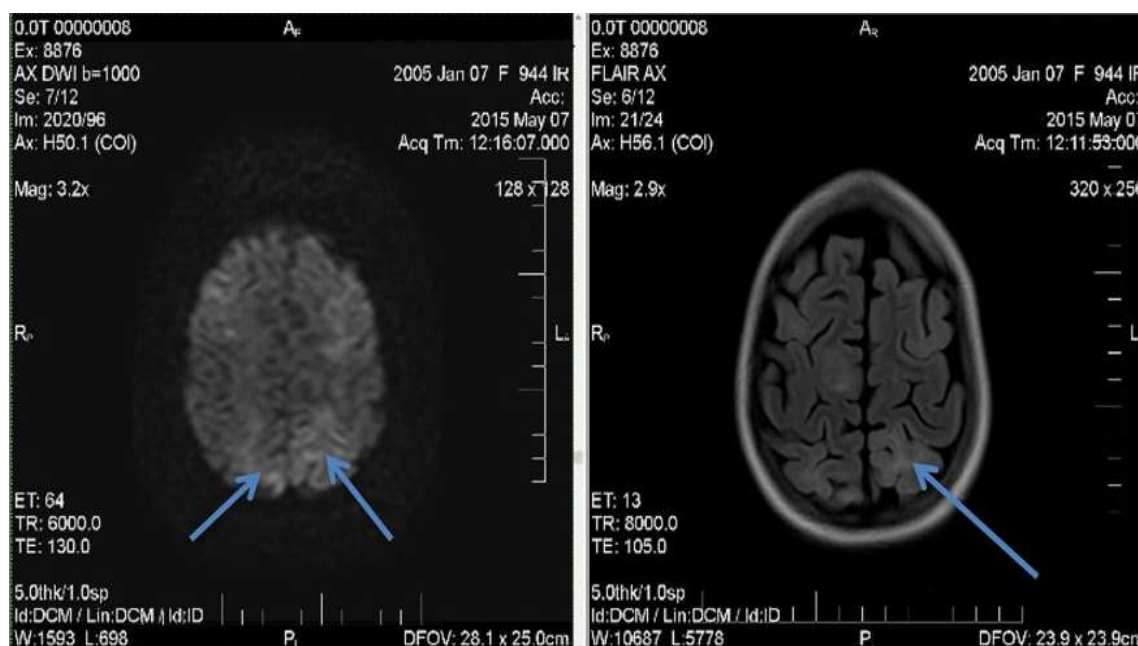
MRI diffusion and FLAIR: cortical hyperintensity in the parietal superior gyrus - white matter injury
